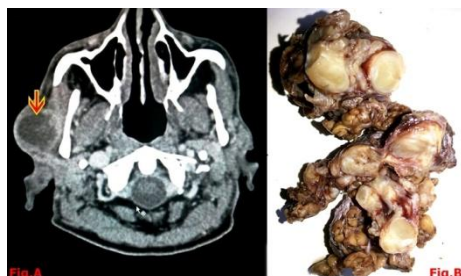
CT scan showing well defined hypoattenuated mass (red arrow) arising in the parotid gland.
